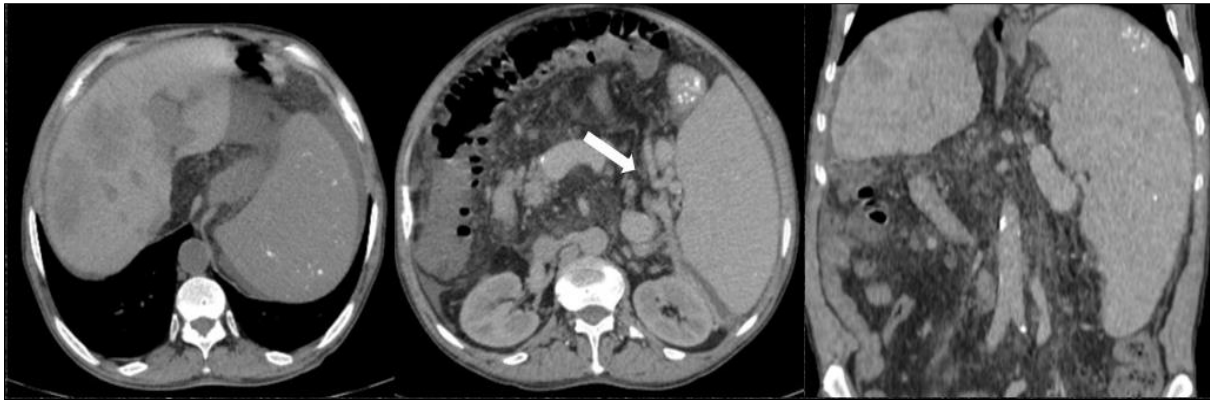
Portal phase CT showing features of portal hypertension, including a dysmorphic liver with irregular nodular contours, significant splenomegaly, and prominent perisplenic collateral venous circulation and associated ascites
